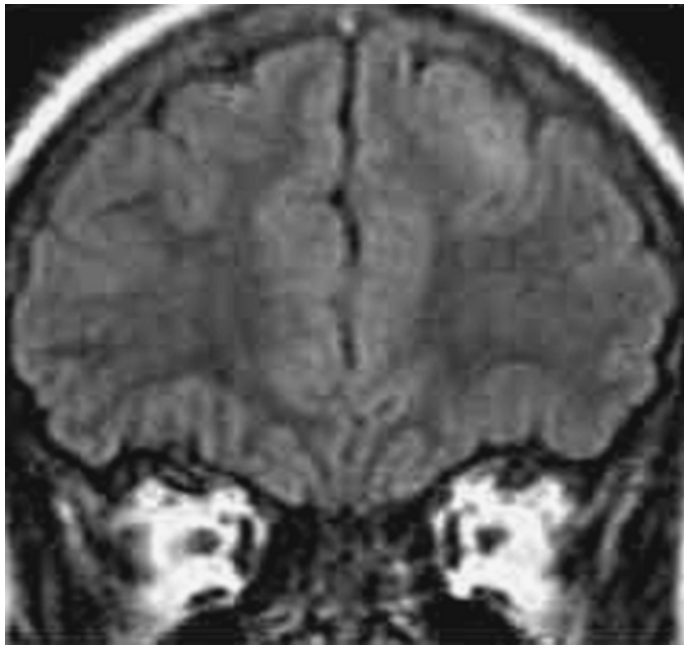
Focal cortical dysplasia (FCD). Left frontal lobe shows in this coronal fluid-attenuated inversion recovery magnetic resonance image a subtle signal abnormality and thickened cortex representing FCD. Pathology showed balloon cells.
